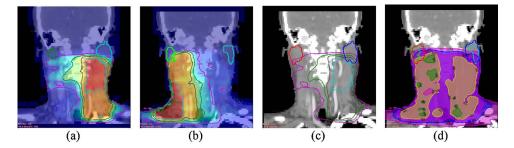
Demonstration of dose deformation and accumulation. (a) Dose of the initial plan overlaid on the first CT scan with the contours of both parotids. (b) Dose of the second plan overlaid on the second CT scan with the both parotids (contoured on the second scan). (c) The deformed initial dose on the second CT scan with the initial parotid contours remapped onto the second CT scans. (d) The sum of doses of both plans on the second CT scan with both the remapped initial parotid contours and the secondary parotid contours. Different color map schemes are used in (c) and (d) to show varieties of the dose visualization options in DIRART.
